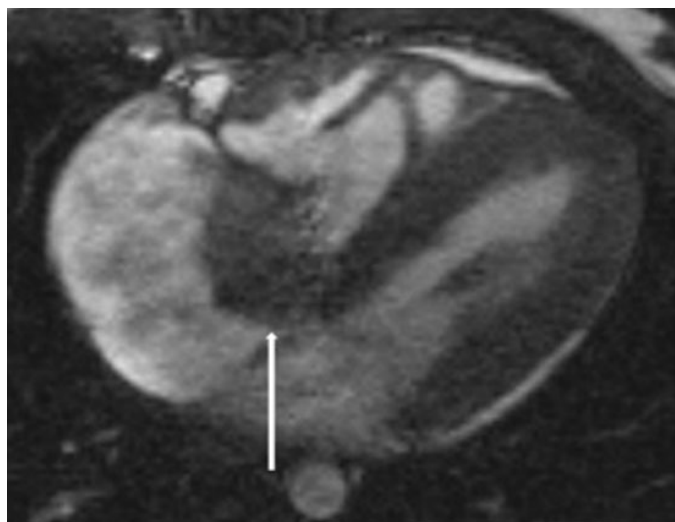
CMR still frame from apical 4 chamber cine steady state free precession (SSFP) imaging showing a large isointense, homogenous mass attached to the septal leaflet of the tricuspid valve leaflet (white arrow).
